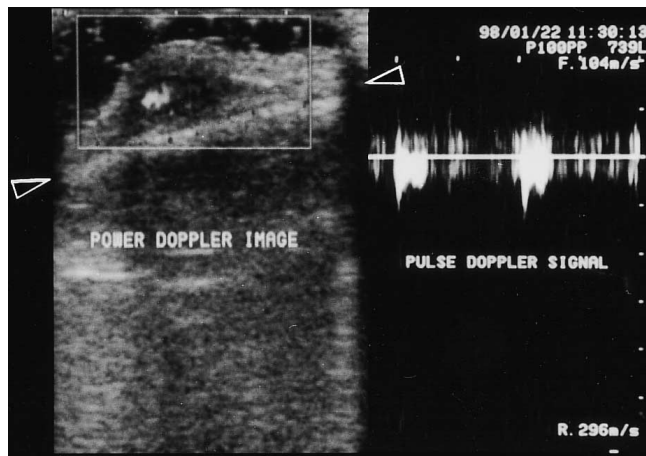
Doppler ultrasound scan of the lesion. Left: power Doppler image. Note the well-defined subcutaneous low echogenic mass with blood flow, indicated by the central whitish area. Cranial bone (arrowhead). Right: pulse Doppler image. Note the pulsatile and arterial flow.
